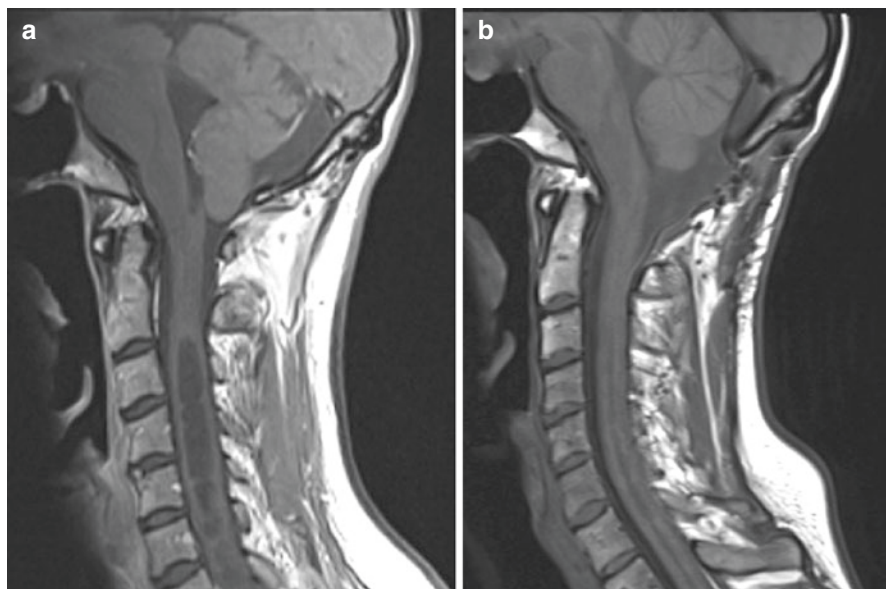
(a) The T1-weighted MRI scan of a 47-year-old woman with a Chiari I malformation and a syrinx C3–Th2. (b) After decompression of the foramen magnum with a duraplasty, the CSF passage is free, and the syrinx has decreased
